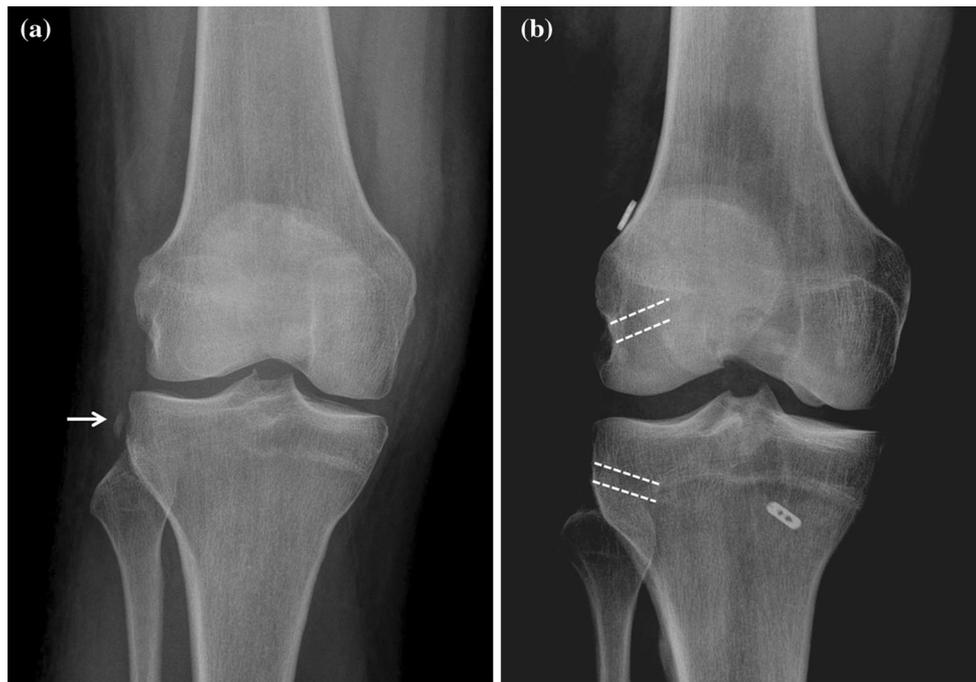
AP radiographs of a right knee following a twisting injury, a demonstrating a Second avulsion fracture at the insertion of the ALL (*arrow*), b post-operatively, following combined ALL and all-inside ACL reconstruction (ALL fixation sockets marked by *dashed lines*)
